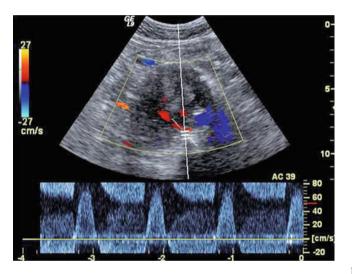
To and Fro Doppler signal at the origin of a posterior lumbar leak, systole (inflow) and diastole (outflow)
